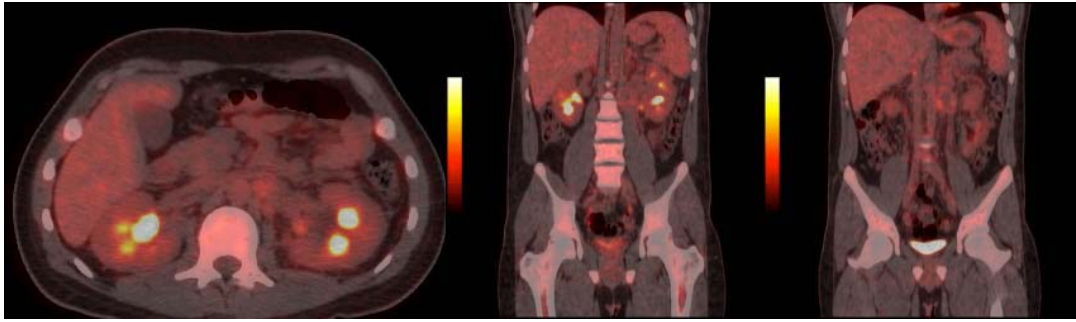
F-18 FDG PET/CT.
